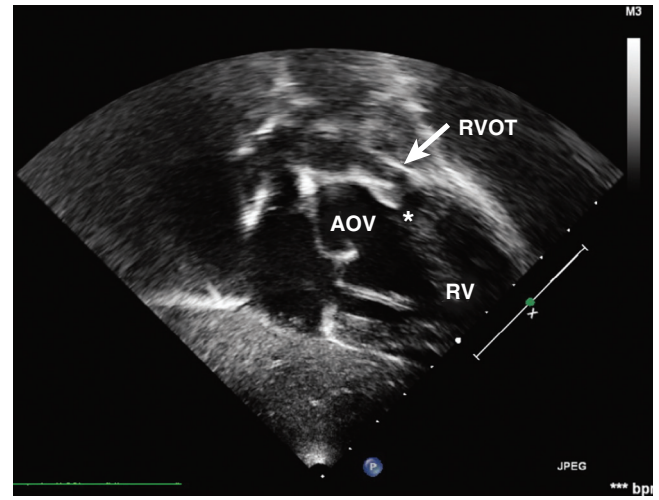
■ Preoperative two-dimensional echocardiographic image, oblique subcostal view, showing the right ventricular outflow tract (RVOT) and the deviated infundibular septum (asterisk). AOV, Aortic valve; RV, right ventricle. (Courtesy Professor Ornella Milanese.)
